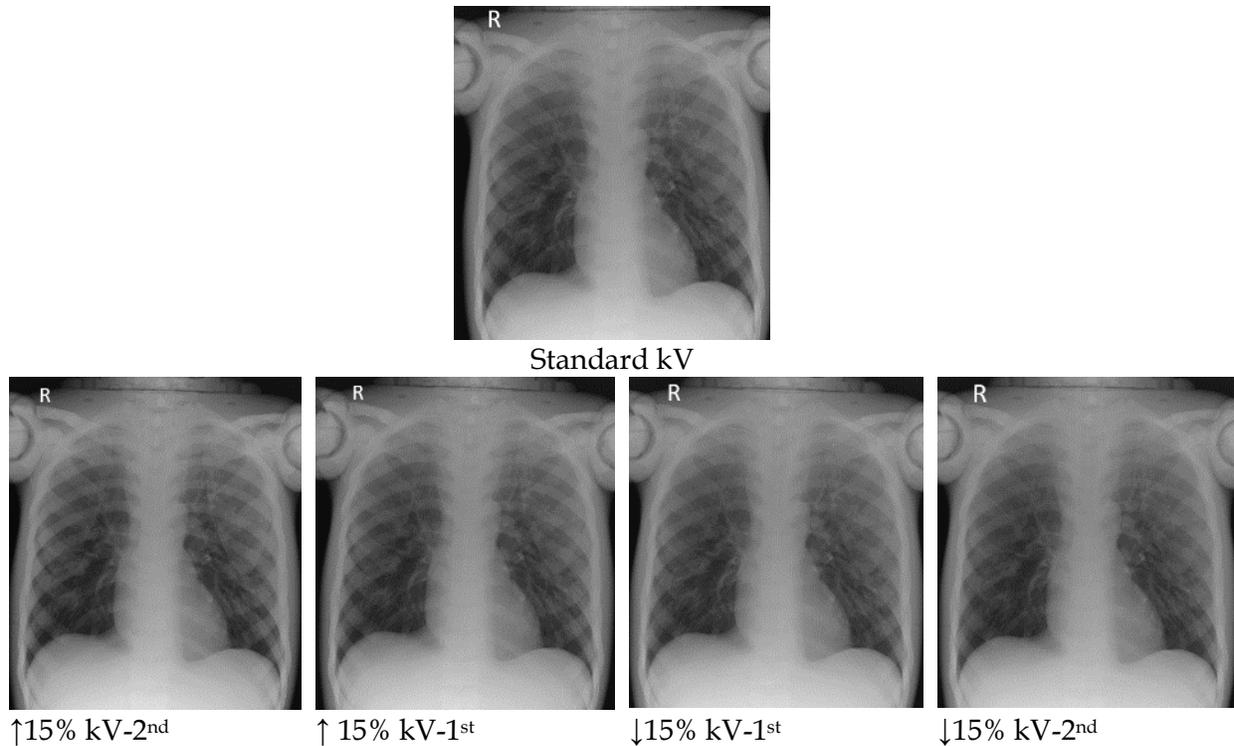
Radiographic image of 15% kV rule method
